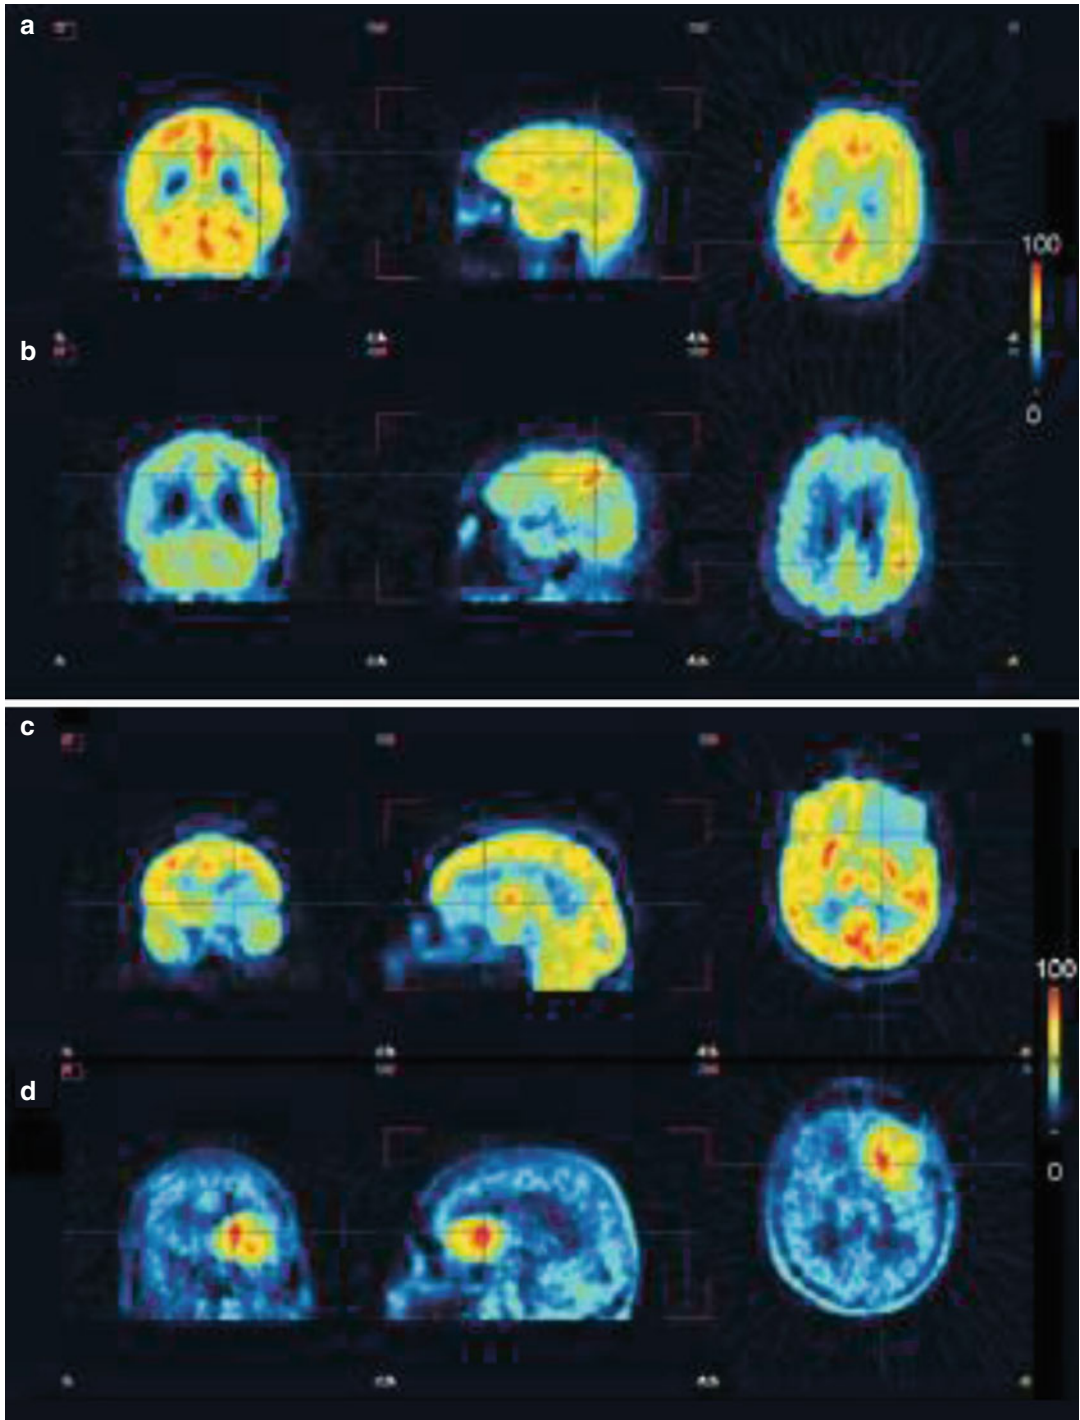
Combined [^{18}F]-FDG (*upper row*) and [^{11}C]-MET (*lower row*) PET studies. Patient #1 (a, b) displays tumor recurrence of the primary glioblastoma grade IV, which is easily detectable with [^{11}C]-MET (b) but not on
